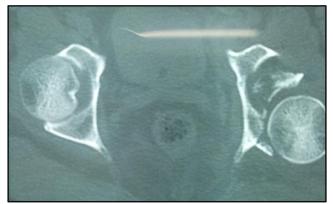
CT Scan showing acetabular wall fracture with fragment in joint
